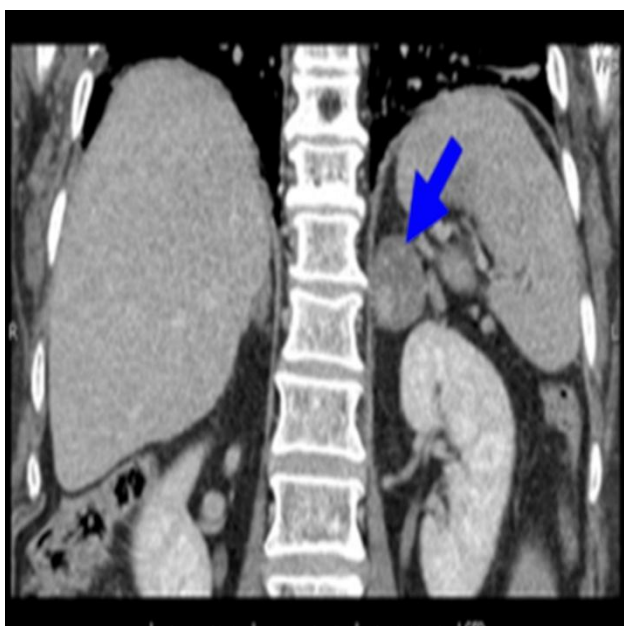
Axial contrast-enhanced CT image of the abdomen showing a well-defined isodense mass (arrow) in the left adrenal gland. The lesion measures 4.5×4.5×6 cm, demonstrates mild heterogeneous enhancement, and is separate from adjacent organs. No vascular invasion is noted.
